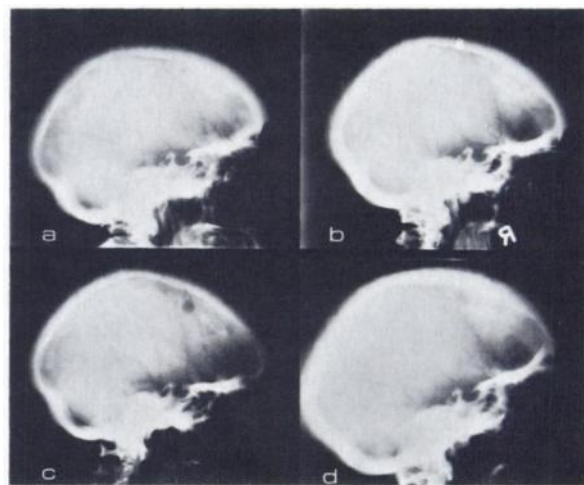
Patient 1 (as in Fig. 3). (a) Radiograph shows Paget's disease of entire skull. (b) One yr later: There is possible focal osteolysis in vault of skull. (c and d) 10 and 17 mo still later: Distinct lesion is visible, consistent with either metastasis or osteoporosis circumscripta.
